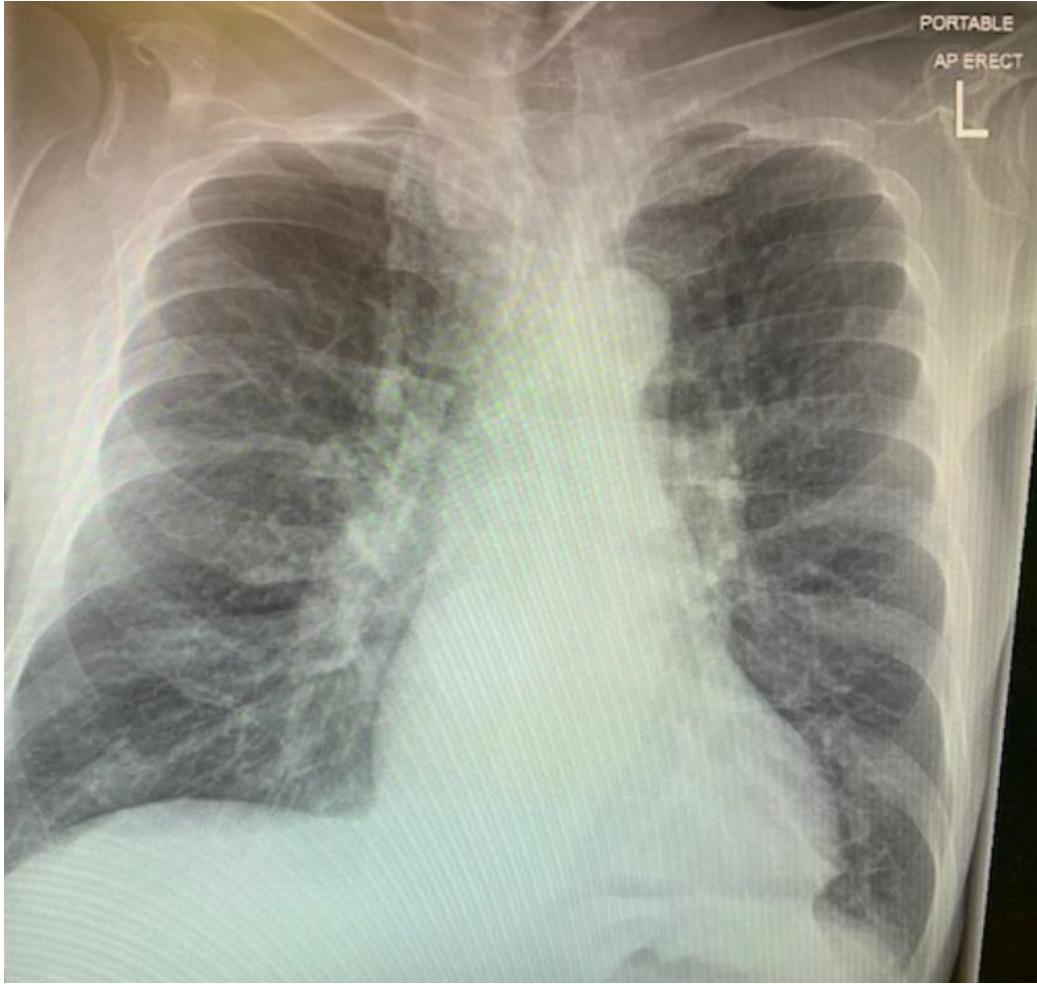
Chest X-ray/CXR on 3rd admission showing no features suggestive of active COVID-19 infection
